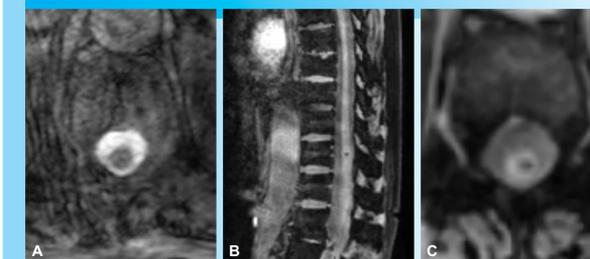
Thoracic spine MRI. Central hypointensity is very subtle on axial 2D MEDIC (A), much more obvious on 3D MEDIC (B, sagittal, C, reconstructed axial).
